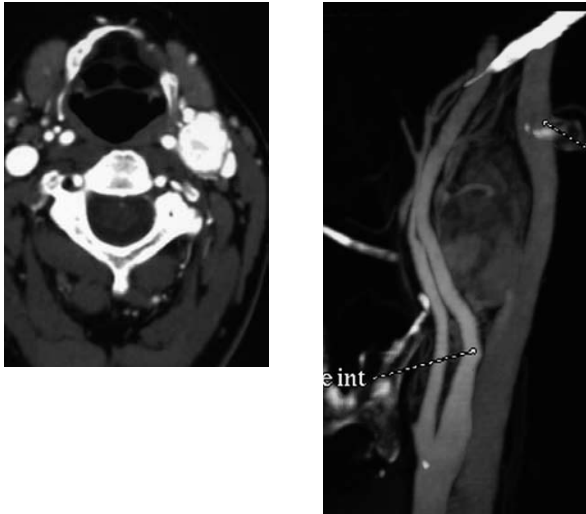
Contrast-enhanced CT scan of neck showing left mass 31.4 x 15.6 mm compressing internal jugular vein and displacing anteriorly external and internal carotid arteries.
